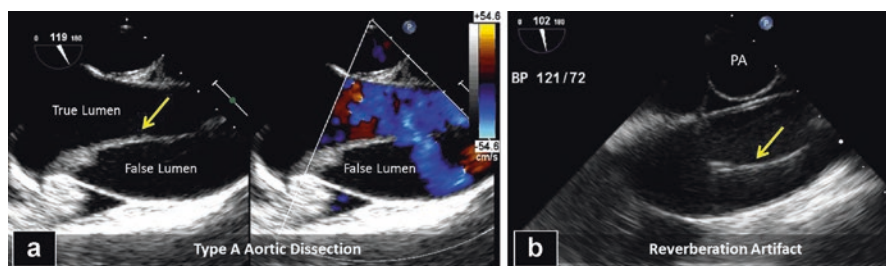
Dissection. (a) Type A aortic dissection with separation of aorta into true and false lumen with color Doppler flow demonstrating communication between lumens. (b) Reverberation artifact from pulmonary artery mimicking aortic dissection. PA Pulmonary artery
